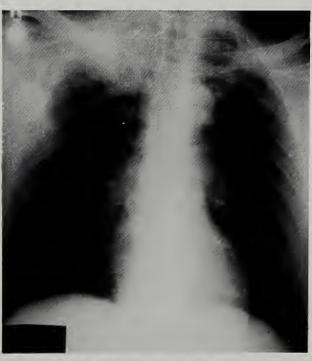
Chest x-ray showing the presence of a right apical lung
